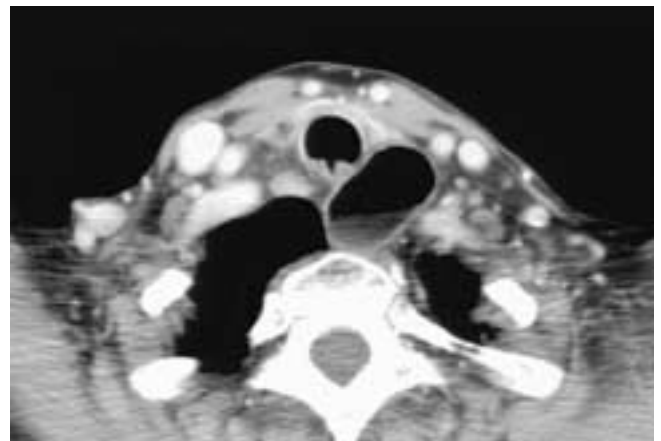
Axial contrast-enhanced CT scan (A) shows a large Zenker's diverticulum (*arrow*) with an air-fluid level. The diverticulum is directly behind the cervical esophagus (E). Axial contrast-enhanced CT scan (B) on another patient shows a Zenker's diverticulum posterior to the cervical esophagus. The diverticulum contains air in a nondependent position anteriorly, food products in the middle, and oral contrast layering posteriorly. Axial contrast-enhanced CT scan (C) on a third patient shows a collection of air (*arrow*) adjacent to the right side of the cricopharyngeus muscle. This was a Zenker's diverticulum.
